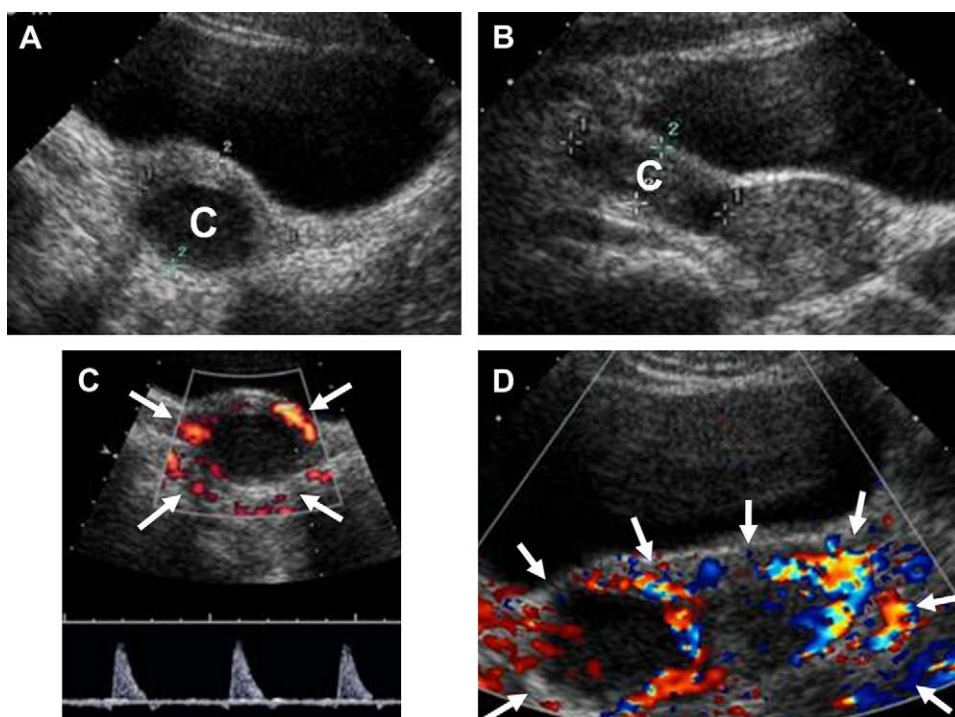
Transabdominal ultrasonography (A,B) shows a large, thickwalled cystic lesion (C) of indeterminate origin. Doppler flow studies (C,D) demonstrate normal circumferential blood flow to both ovaries (arrows).
